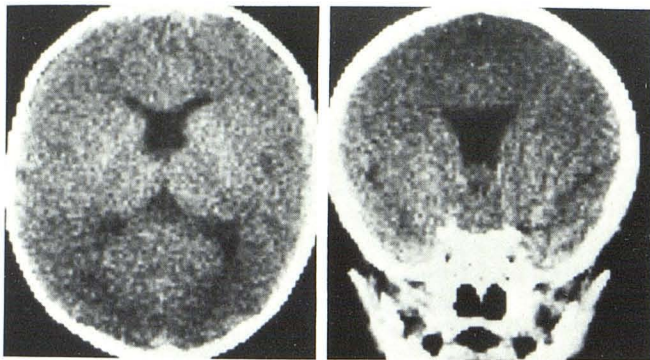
Axial (A) and coronal (B) CT scans. Roofs of anterior horns of lateral ventricle are flattened; septum pellucidum absent.
